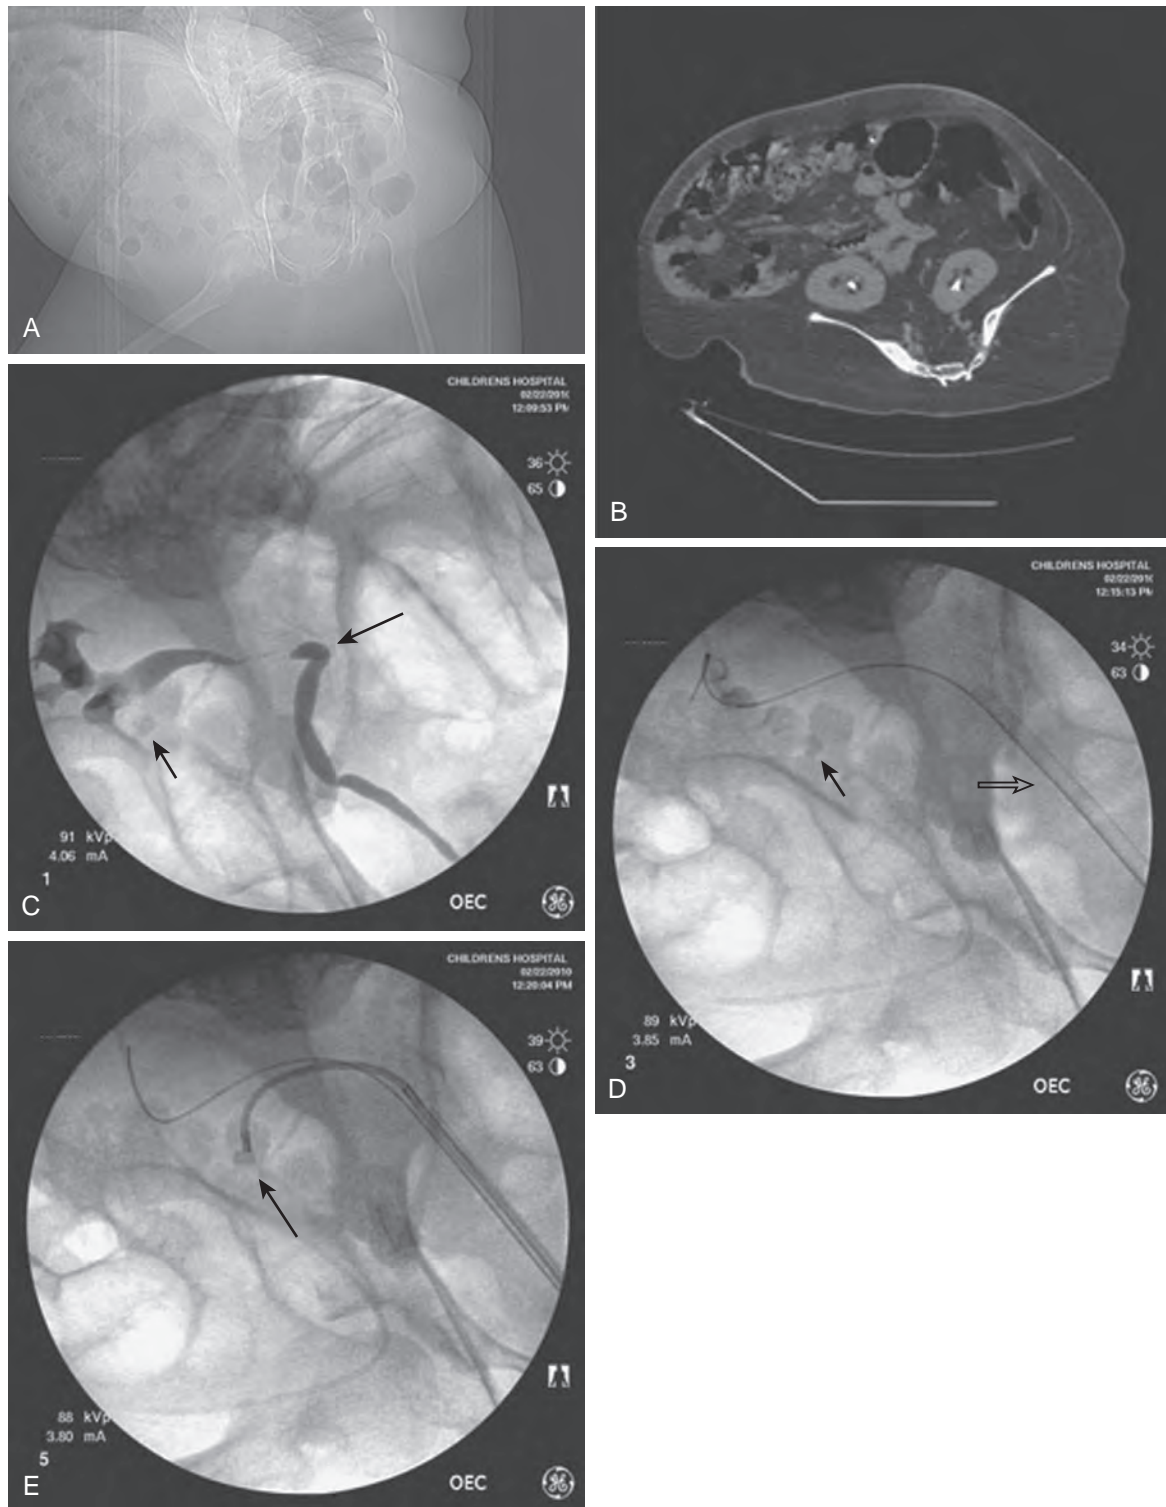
Altered anatomy in a 17-year-old boy with spina bifida who underwent a high thoracic myelomeningocele closure at birth (A). A computed tomography scan performed for a gross hematuria workup revealed bilateral nephrolithiasis in pelvic kidneys (B). The right retrograde pyelogram (C) demonstrated the lower pole stone (*short arrow*) and a tortuous ureter almost taking a perpendicular course (*long arrow*). Placement of a ureteral access sheath (D) straightened the ureter (*open arrow*). This allowed easier access to address the stone (*short arrow* in D) with a flexible ureteroscope (E).
